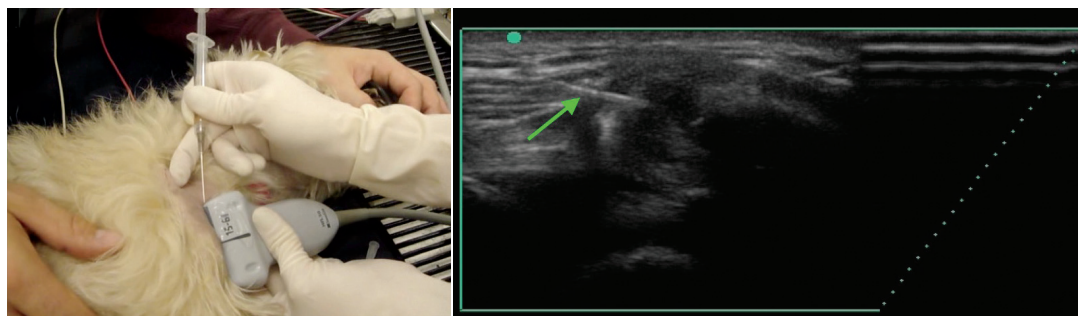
Ultrasonography-guided injection of BMAC and PRP into the supraspinatus tendon. The green arrow points to the needle being inserted into the supraspinatus tendon.
